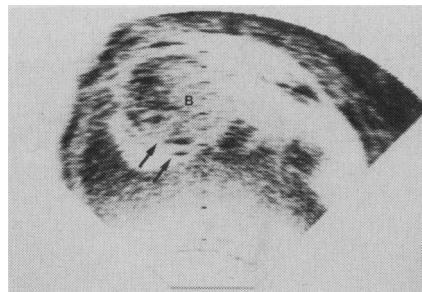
Transverse ultrasound scan of fetus at 15 weeks' gestation, showing double lines (arrows) around body (B) and massive edema.
